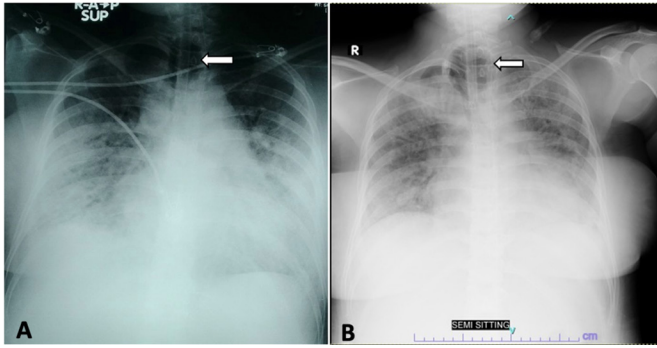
Chest radiographs taken on day 18 (A) and day 35 (B) of intubation, where the patient was being treated for recurrent episodes of pneumonia. Note the hyperinflated endotracheal cuff (represented by the arrow) seen as a cystic lucency at the level of the trachea. Alveolointerstitial opacities throughout both lungs, with peripheral predominance—characteristic of COVID-19 pneumonia, were also noted. A thin visceropleural line was seen along the periphery of the right mid-to-upper lung fields (B) representing a small volume pneumothorax.
